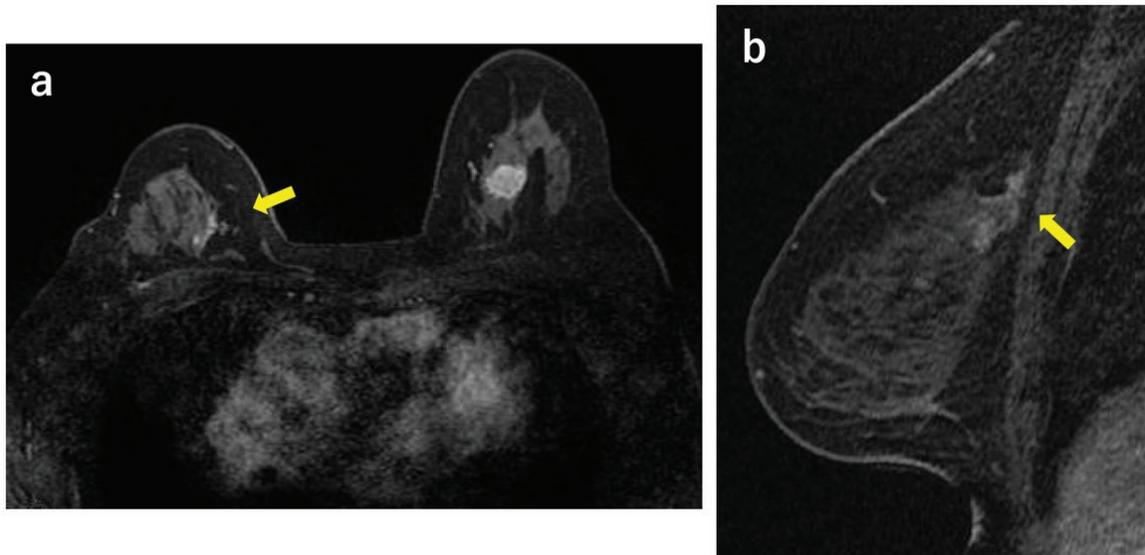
(a, b) case 9: a 67-year-old woman, a *BRCA2* pathogenic variant carrier, was diagnosed with left breast cancer (T2N0, triple-negative breast cancer) 17 years after right breast-conserving surgery and sentinel node biopsy with preoperative chemotherapy for right breast cancer. Preoperative staging magnetic resonance imaging (MRI) revealed category 4 non-mass enhancement with branching in the right inner upper quadrant. MRI-guided biopsy identified triple-negative invasive ductal carcinoma. She was diagnosed with in-breast recurrence in the conserved right breast. Bilateral surgery was performed after preoperative chemotherapy
